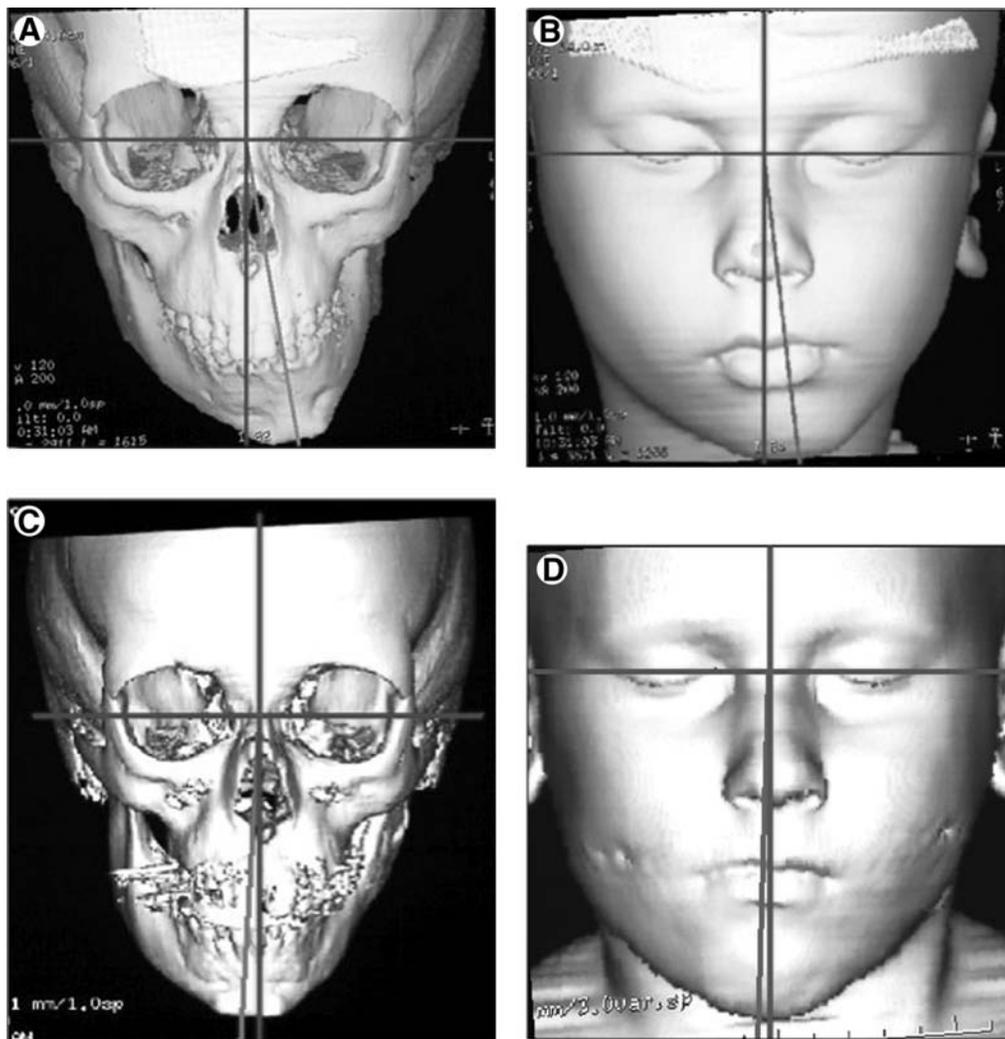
Frontal view of the preoperative 3D CT scan reconstructions showing the skeletal (A) and soft tissue (B) asymmetry. Note the severe mandibular deviation towards the affected side. After distraction, the skeletal (C) and soft tissue asymmetry (D) is corrected by elongating the mandibular ramus. Note the slight overcorrection to the non-affected side needed to overcome anticipated relapse and postdistraction asymmetric growth. (Color version of figure is available online.)
